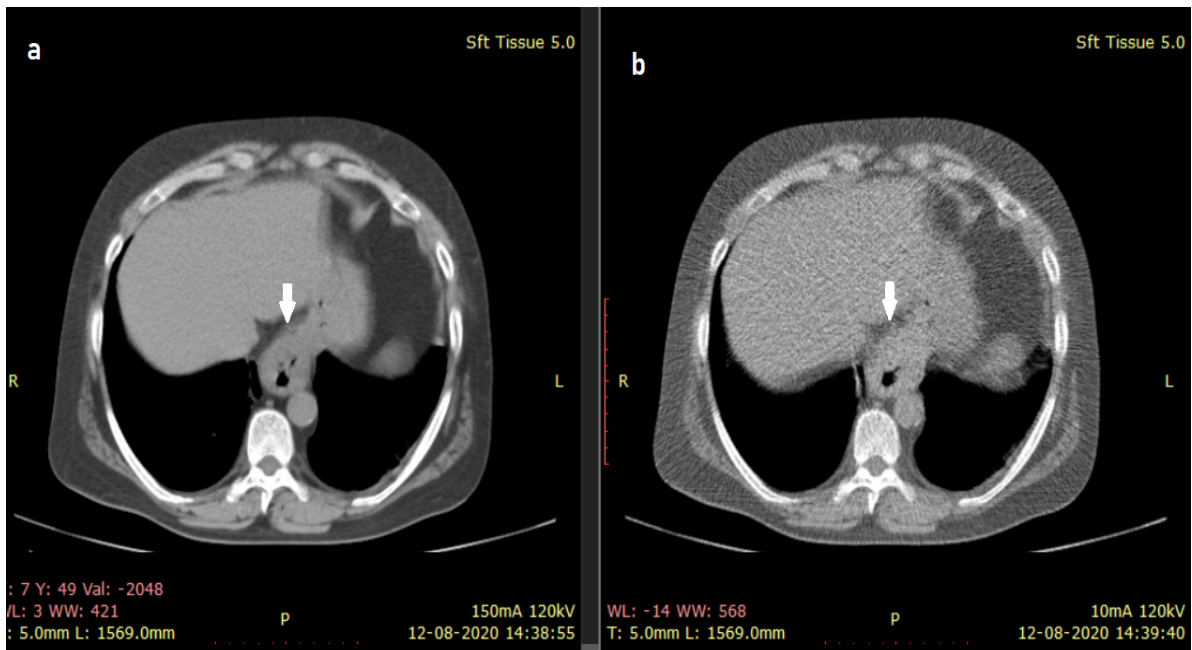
Chest CT scan with Mediastinal Window Revealing Hiatus Hernia
